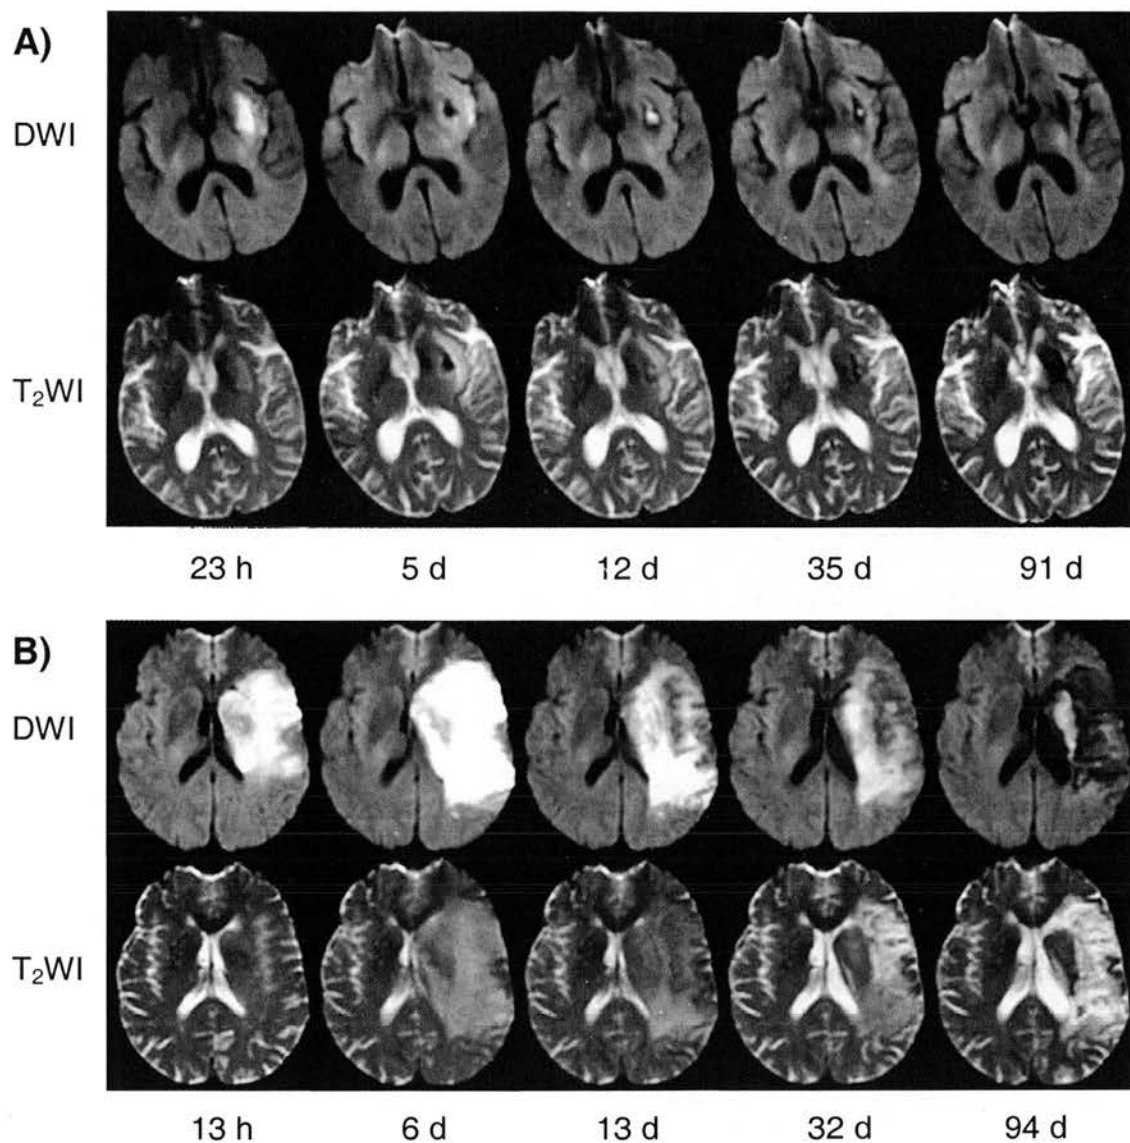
DWI and T₂WI from baseline to 90 days after stroke onset for two patients analysed with the SGAT 'swell tool' program. A) Patient N (with left hemisphere ischaemic lesion), with minimal tissue distortion due to swelling; B) Patient R (with left hemisphere ischaemic lesion). with more extensive tissue distortion due to swelling (particularly at 6 days after stroke onset), and *ex vacuo* effect at 94 days after stroke onset.
